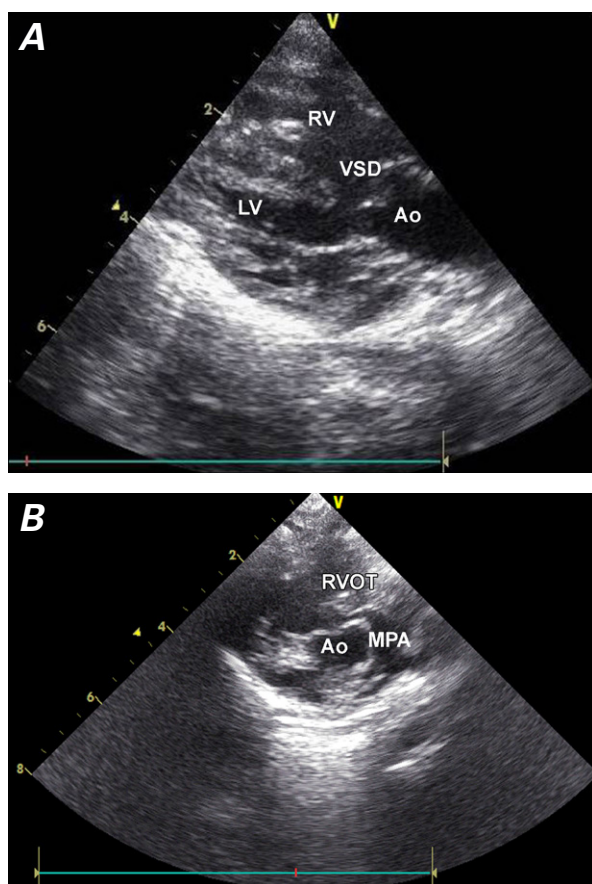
Two-dimensional echocardiograms in A) parasternal long-axis view and B) short-axis view show tetralogy of Fallot with subpulmonic and valvular stenosis.
